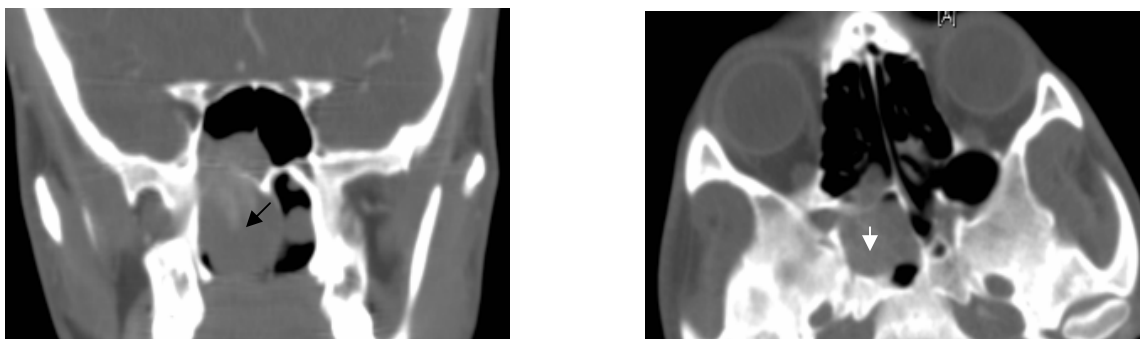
Coronal CT scan shows a mass filling right nasal cavity and sphenoid sinus (*black arrow*).b. Axial CT scan filling right sphenoid sinus(*white arrow*).
